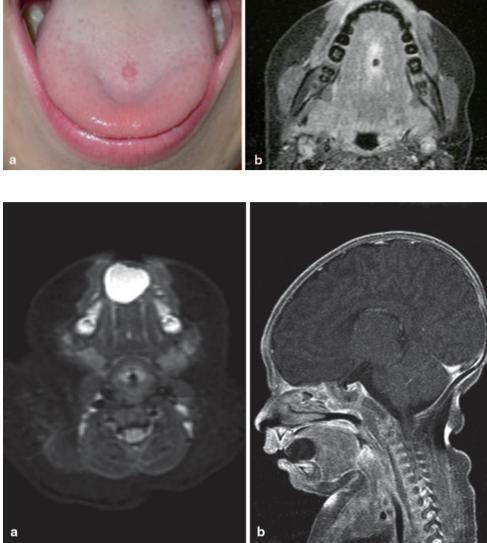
A 7-week-old girl with a tongue foregut duplication cyst. a An axial fast spinecho inversion recovery MRI reveals a unilocular, sharply circumscribed midline lesion that is isointense with cerebrospinal fluid located within the anterior aspect of the floor of the mouth. b A gadolinium-enhanced, fat-suppressed sagittal T1-weighted image reveals a cystic mass that does not enhance
